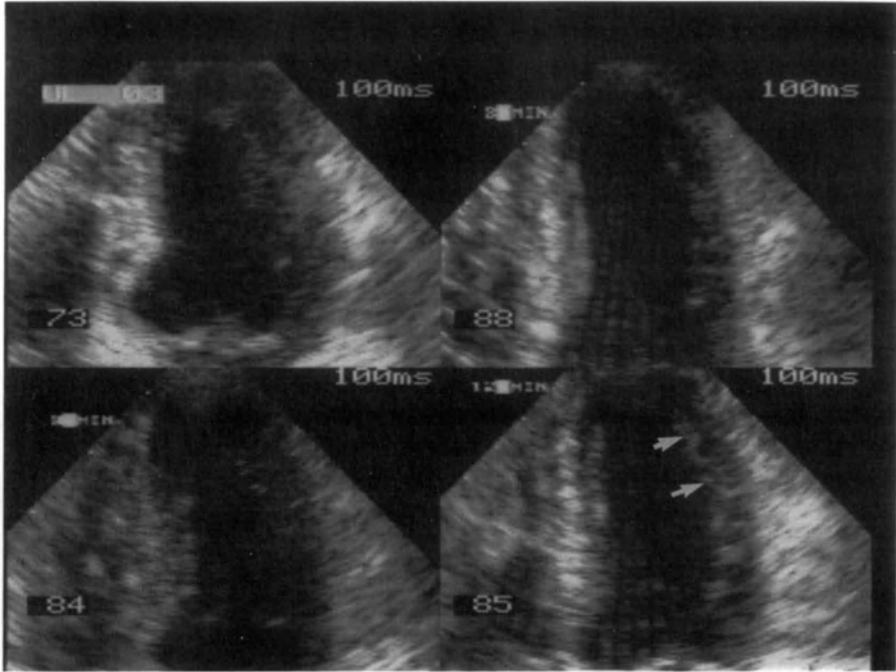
Freeze-frame systolic images at rest (upper left), before (upper right) and after (lower frames) the second dose of a high-dose dipyridamole echocardiography protocol. The anterior wall demonstrates reduced excursion after the second dose (arrows). Note the absence of a hyperkinetic response to stress (contrast with Figure 4.1), and a minor increment of heart-rate.
